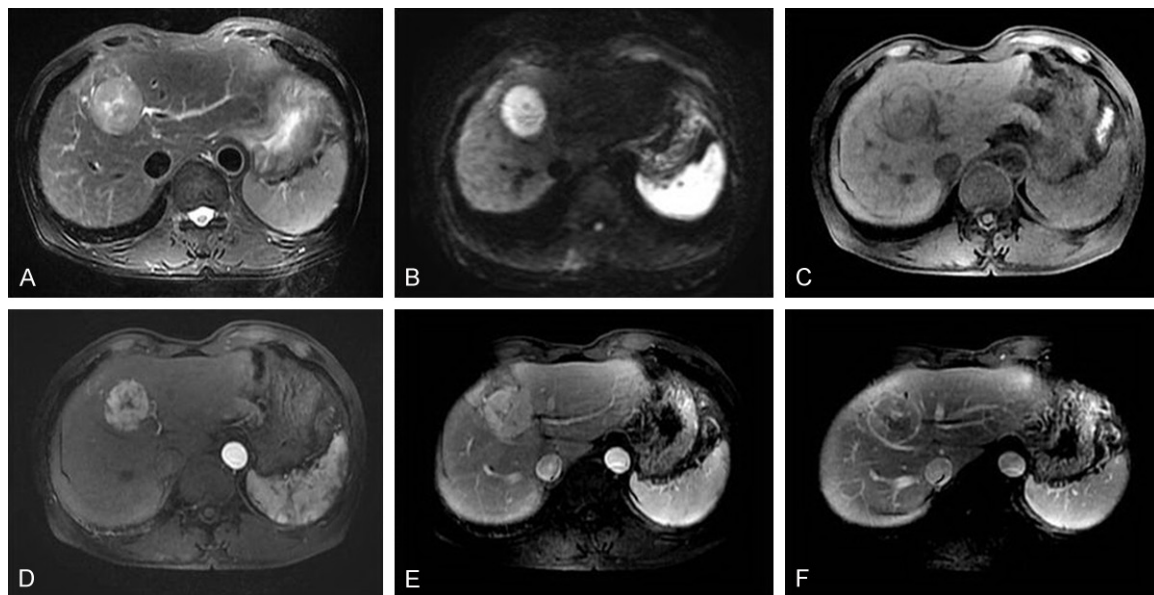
A solitary hepatocellular carcinoma of the single nodular type in a 67-year-old man confirmed as MVI-negative by pathologic analysis. A T2-weighted image (A) and a diffusion-weighted image (B) show hyperintensity. A T1-weighted image (C) shows a hypointense tumor in segment IV. T1-weighted images at arterial phase (D), portal-venous phase (E), and equilibrium phase (F) show an arterial phase enhancing tumor and washout on equilibrium phase. A coronal image also shows a smooth tumor-normal parenchyma interface. Abbreviation: MVI, microvascular invasion.
